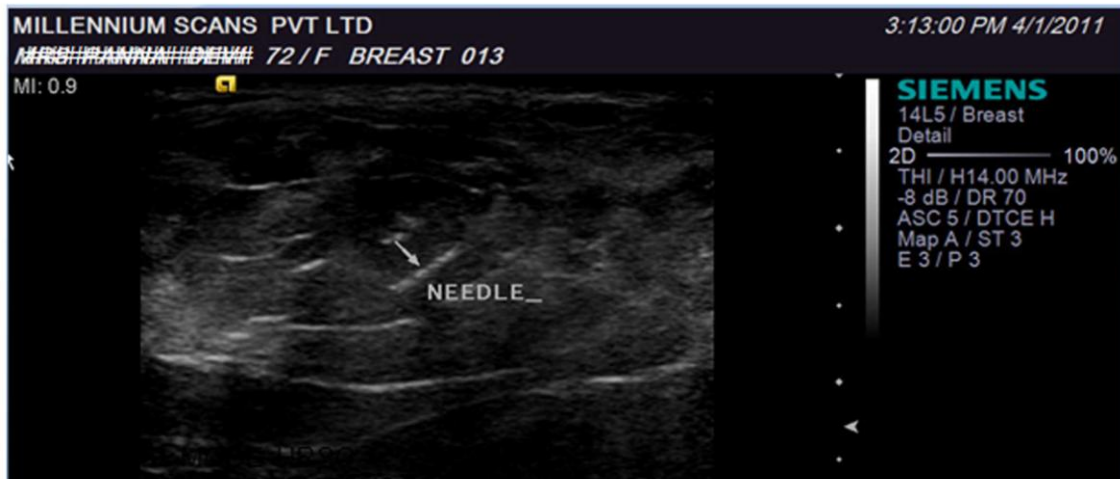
ELASTOSONOGRAPHY GUIDED FNAC/FNAB FROM BREAST LESION
